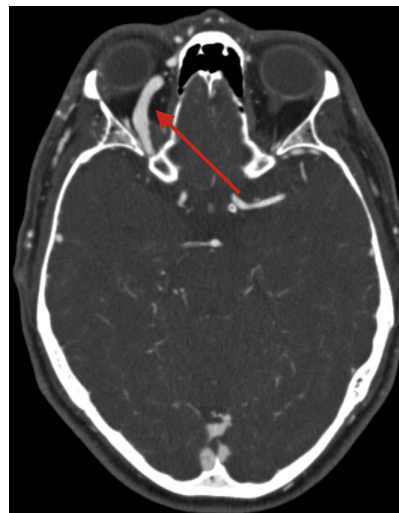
CT angiography (axial view) showing abnormal dilatation of the ophthalmic vein (arrow), causing local mass effect.
